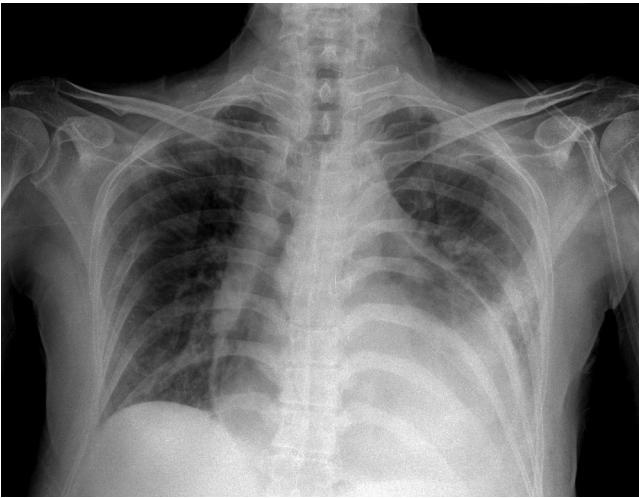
Chest X-ray of the patient showing pneumomediastinum.
